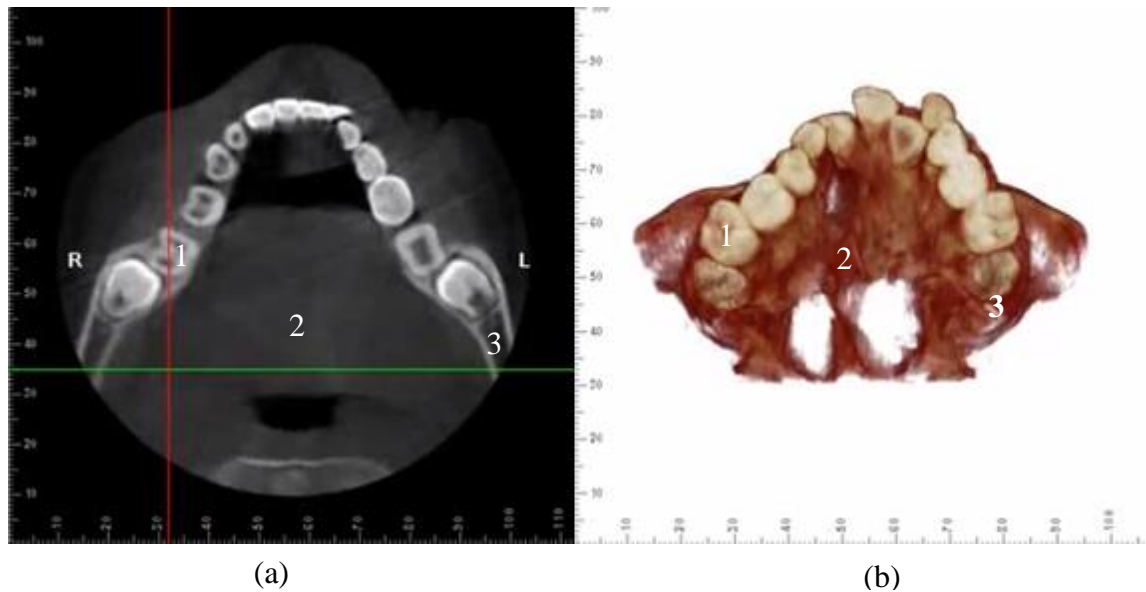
(a) CT of axial slice of maxilla, (b) 3D anatomical view of dental CT (CBCT) reconstructed from (a) with sections of 1 (tooth), 2 (soft tissue), 3 (jaw bone). All structures are clearly visible with no metals. [Modified from [45]].
